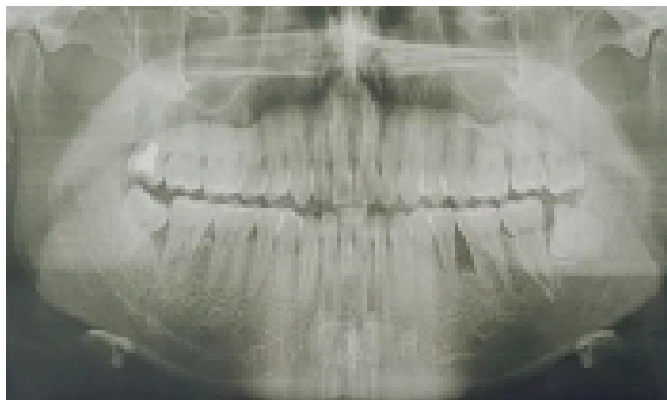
Panoramic radiographic.
